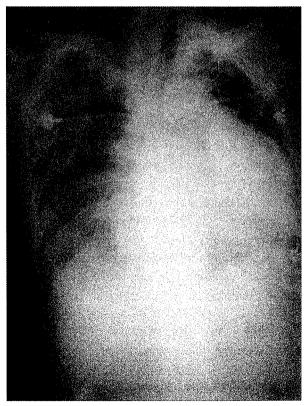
Chest radiography after operation shows improvement of the cardiomegaly with calcified plaque in the left pleural space.
